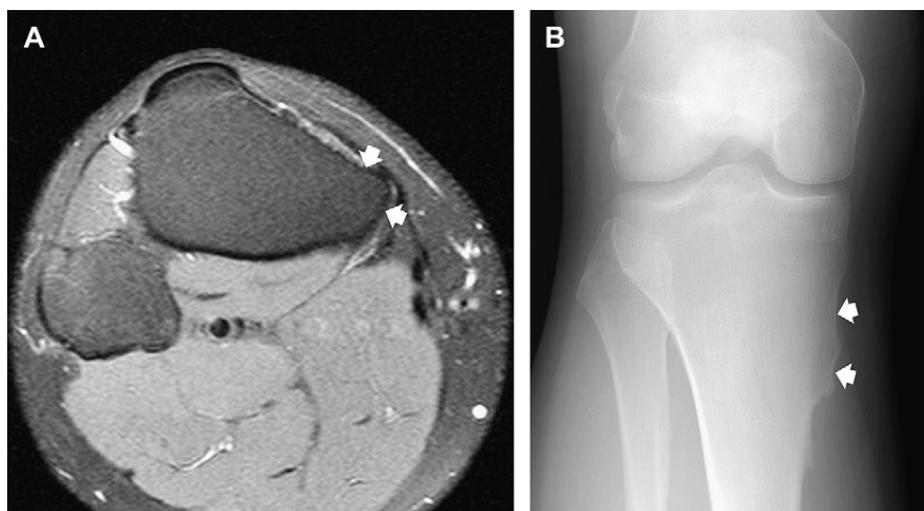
Osteochondroma in the proximal tibia of a 33-year-old man. (A) Axial fat-suppressed proton density (TR/TE; 4000/26) fast spin-echo MR image shows a sessile osteochondroma (arrows) arising from proximal medial tibia. Note cortical and medullary continuity. (B) Corresponding anteroposterior radiograph shows the sessile osteochondroma (arrows).
